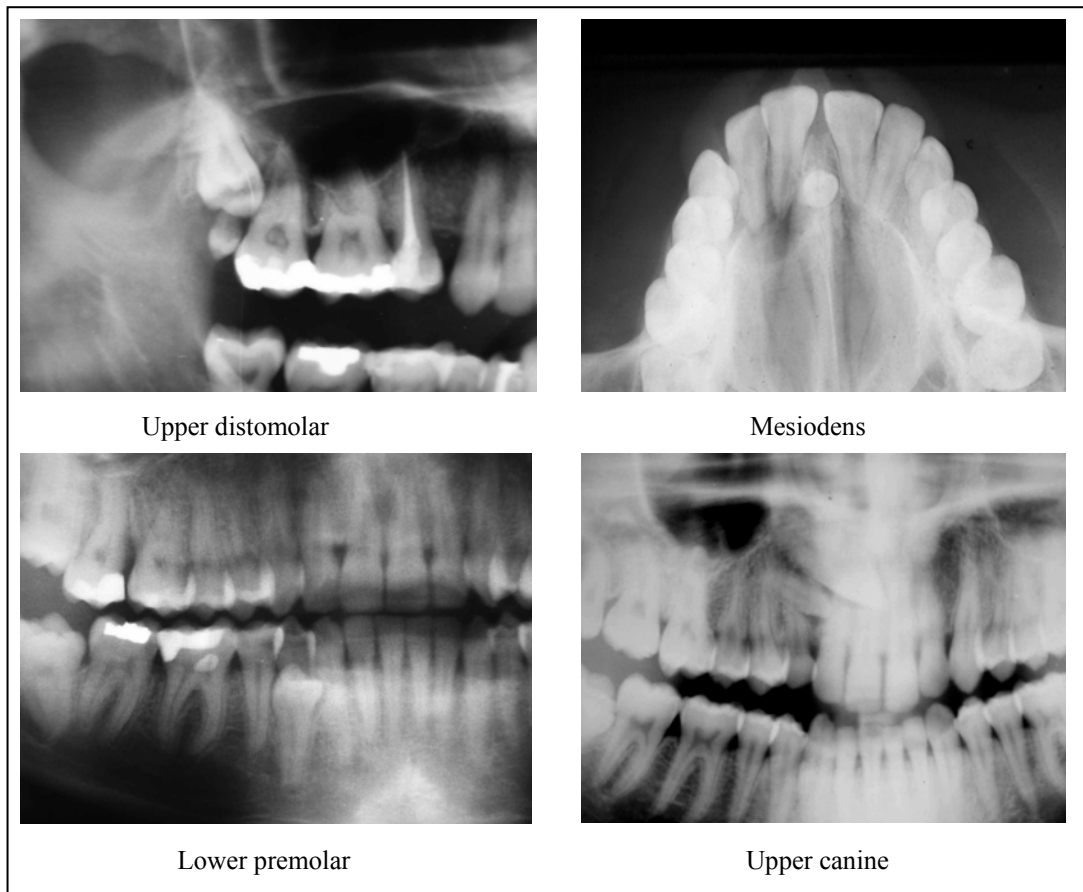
X-ray images showing different supernumerary teeth locations.
